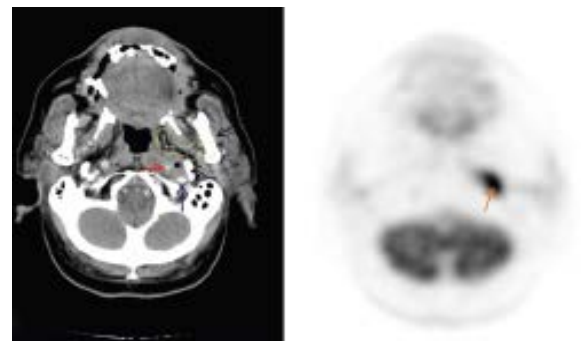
(a) Axial CT scan in soft-tissue window shows a soft-tissue lesion in the left post-styloid parapharyngeal space (asterisk) encasing the ICA (red arrow) and displacing the IJV (blue arrow). Yellow marked area shows pterygoid venous plexus. Black straight arrow points to Mandible. Black curved arrow points to styloid process. (b) FDG PET image at the corresponding level shows FDG uptake in the post-styloid PPS lesion (orange arrow)
